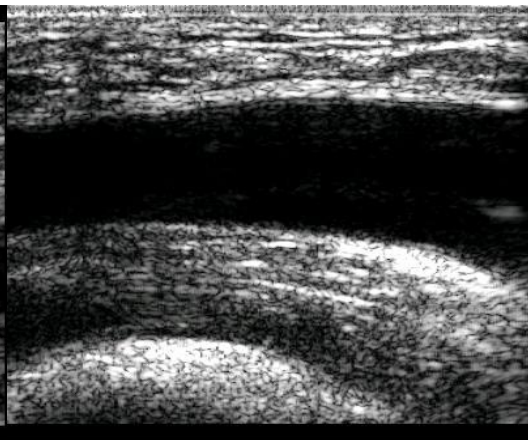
Actual image of femoral artery from B-mode Doppler ultrasound (Vascular Dynamics Lab, McMaster University). Image: a) SCI participant, b) AB participant.
